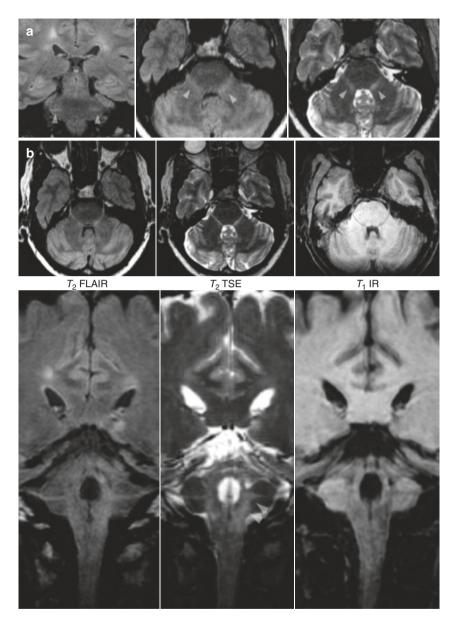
(a) Coronal T2 FLAIR (left), axial reconstruction (middle), and corresponding axial T2 TSE axial reconstruction (right) showing bilateral, well-demarcated, linear hyperintense lesions in the trigeminal root entry zones and tracts of otherwise lesion-free pontocerebellar structures. (b) Axial T2 FLAIR reconstruction (left), corresponding axial T2 TSE reconstruction (middle), and axial T1 IR reconstruction (right) images from the same subjects as imaged in (a). The upper images show the curved plan (green line) in which the lower images were reconstructed. The lower images clearly show abnormal signal extending along the whole transcisternal and intrapontine course of both trigeminal nerves, which become confluent with lesions running rostrocaudally where the pontomedullary trigeminal nuclei would be found (arrowheads). (Adapted from the RJ Mills, British Journal of Radiology, 2010)
